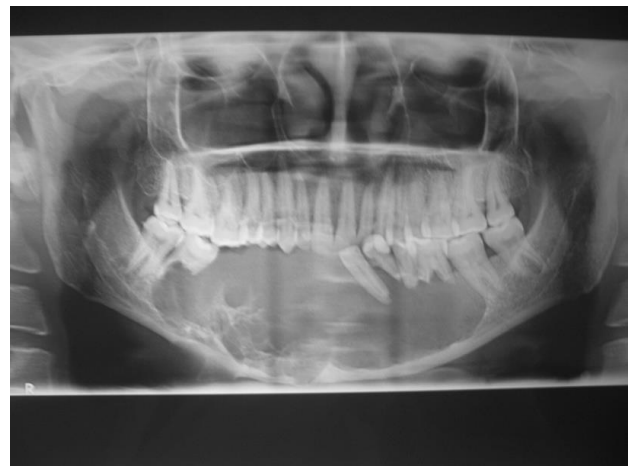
Radiograph showing multilocular radiolucency extending from 37 to 47 and root resorption in relation to 36,35,34,33 and 47.
